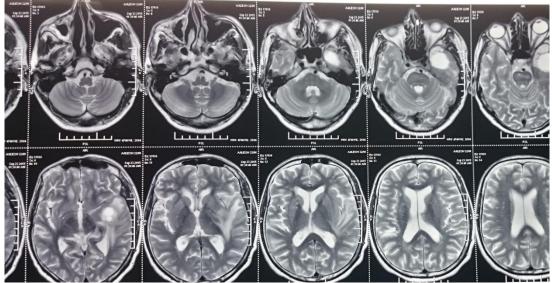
MRI T2 W image showing left temporal tumor
